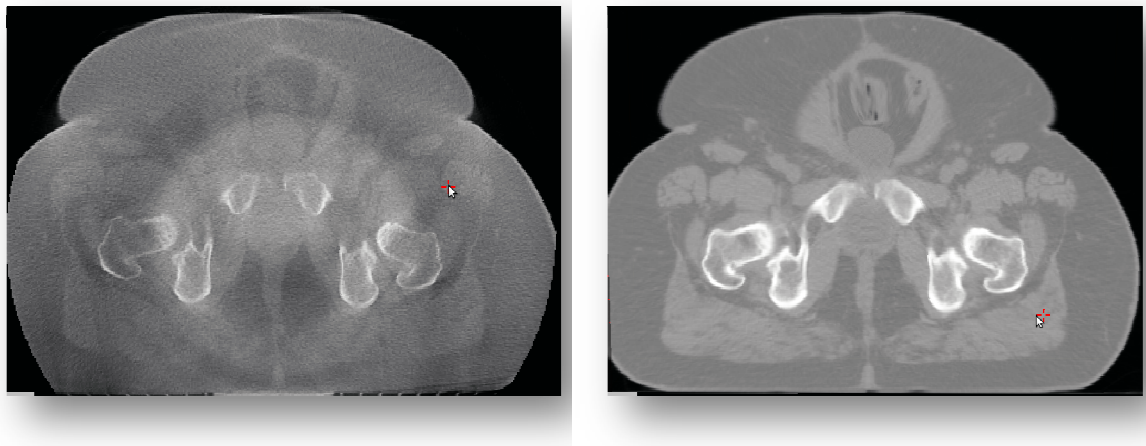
Visual validation of the registration process. Transverse slices of the CBCT (left) and transformed planning (right) images.
